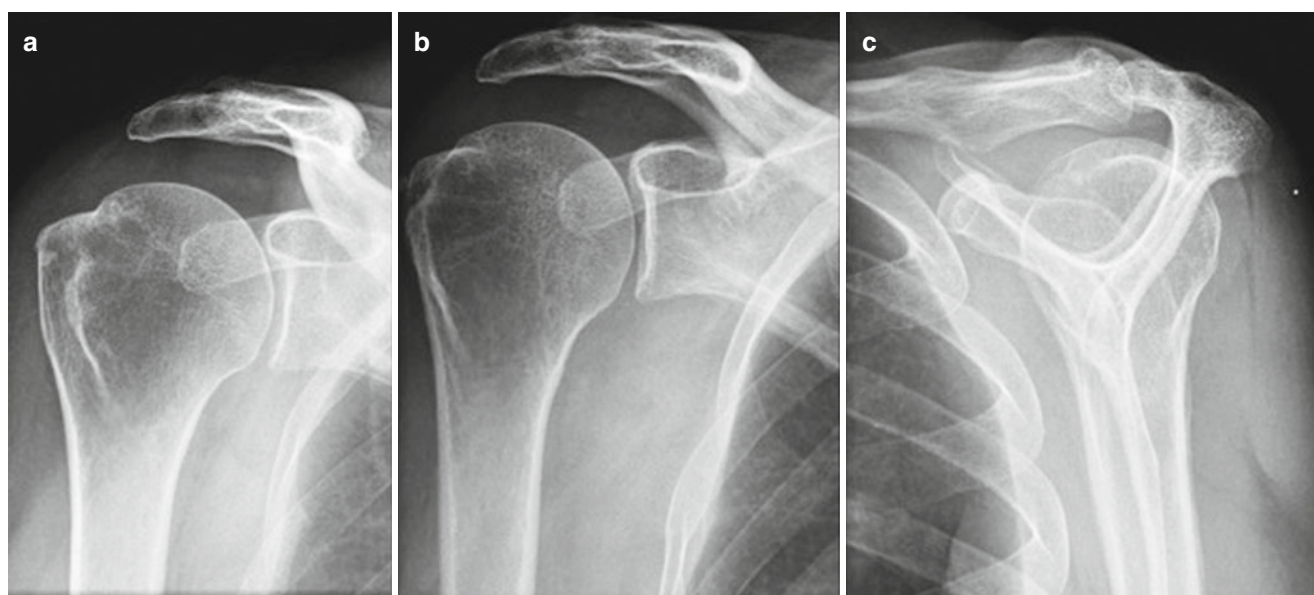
X-rays of a right shoulder: (a) AP in intra-rotation of the limb with the beam etching on the glenoid surface. (b) AP view obtained with the arm in external rotation position. (c) Outlet view. The X-ray
